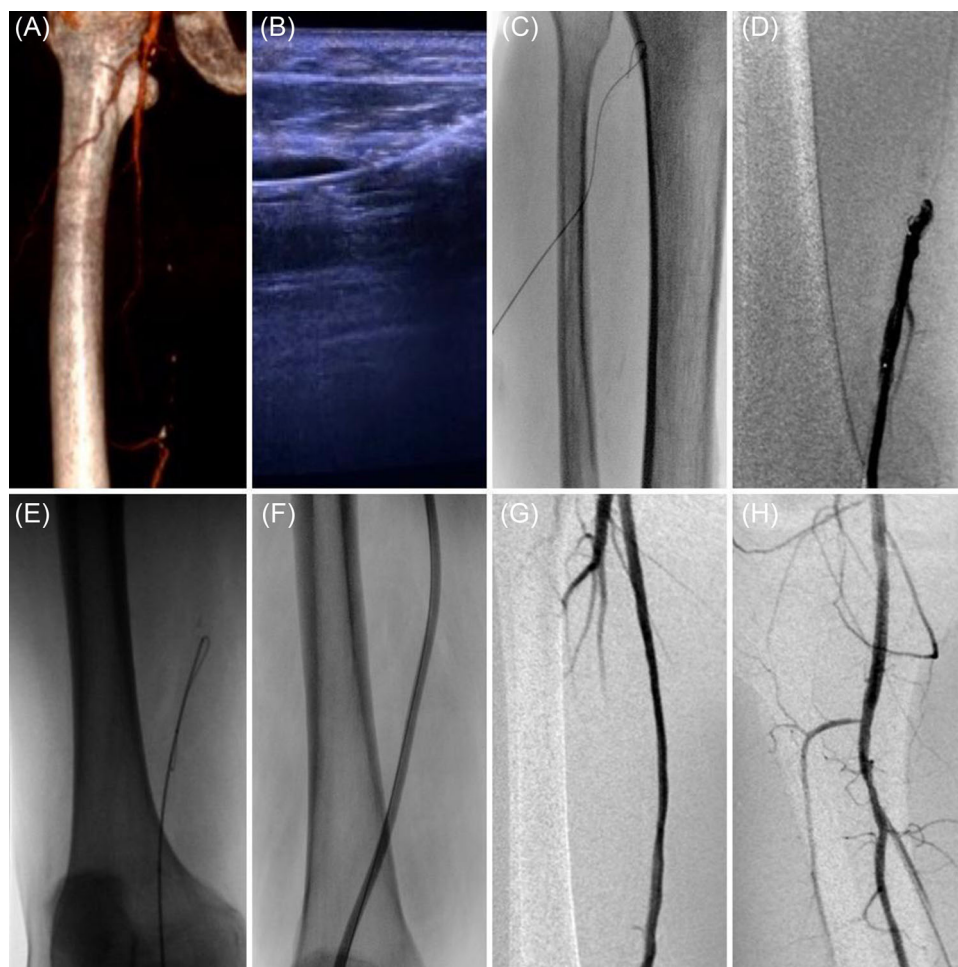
3D reconstruction of a computed tomography angiography showing occlusion of the right superficial femoral artery (A). Us-guided access to the proximal tract of the anterior tibial artery (B), with guidewire advancement under fluoroscopic guidance (C). The subsequent angiography shows the distal end of the occlusion (D). Successful retrograde crossing with percutaneous transluminal angioplasty (E, F). Digital subtraction angiography demonstrates successful recanalization of the right superficial femoral artery and good BTK runoff (G, H). BTK, below-the-knee. [Color figure can be viewed at wileyonlinelibrary.com]
